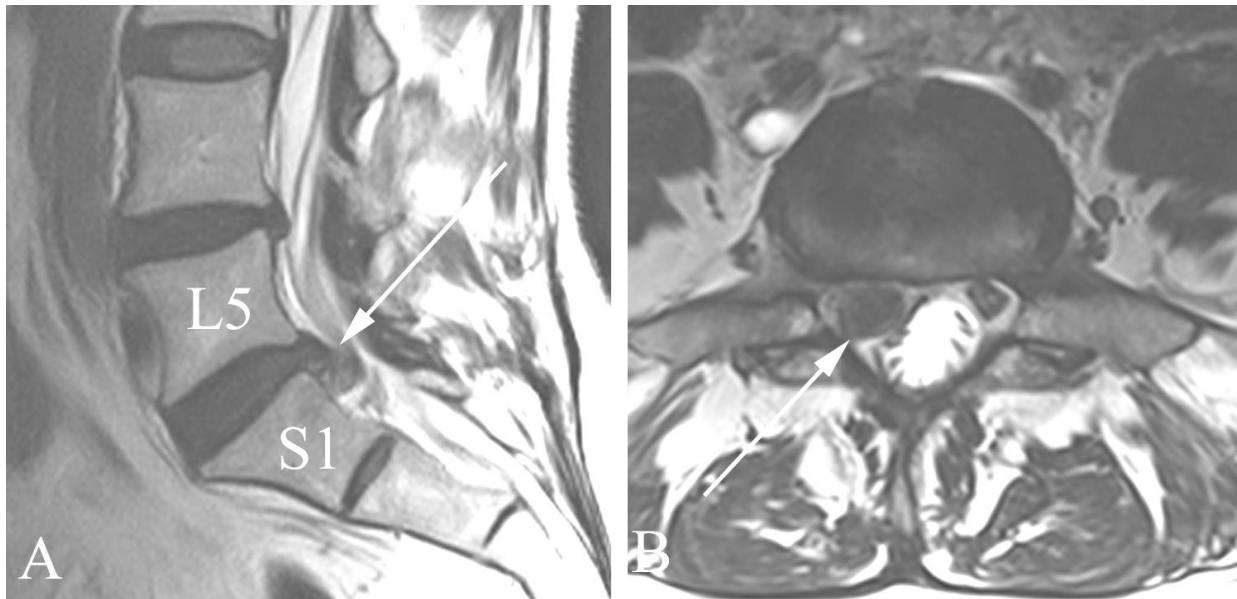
Disc herniation in a 59 year old woman with sudden onset of left back pain radiating down the posterior left lower extremity to the heel. A. Sagittal T2 spine MR image shows a caudally dissecting disc herniation (arrow). B. Axial T2 spine MR shows the disc herniation (arrow) indenting the thecal sac. The sagittal image has been cropped and originally included up to the T11 level.
